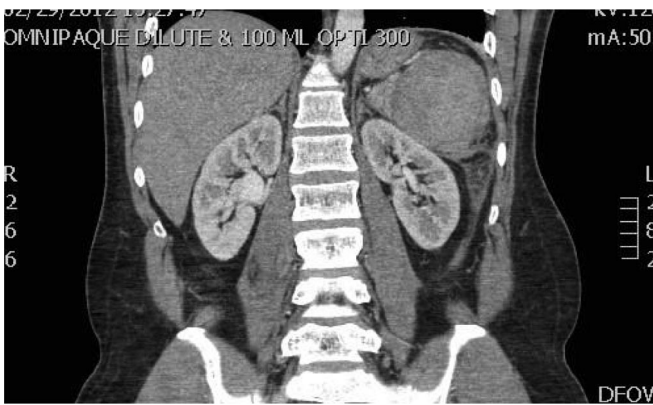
Sagittal CT of Left Upper Quadrant Mass.
